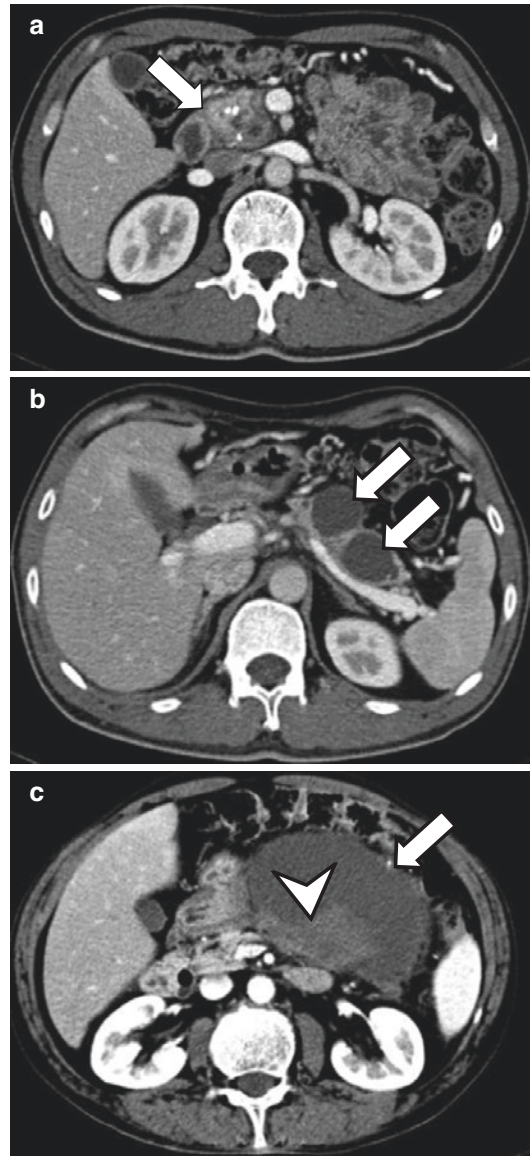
Chronic pancreatitis and pancreatic pseudocyst on CT. A 38-year-old male with history of chronic pancreatitis and chronic upper back pain. CECT axial (a, b) images reveal multiple pancreatic calcifications in the head (arrows) and a bilobulated cystic lesion involving the body and tail of the pancreas (arrow). A 38-year-old male with history of chronic pancreatitis and chronic upper back pain. Contrast CT axial (c) images reveal parenchymal atrophy and a big round cystic lesion with hemorrhage (arrow head) involving the body and tail of the pancreas (arrow)
